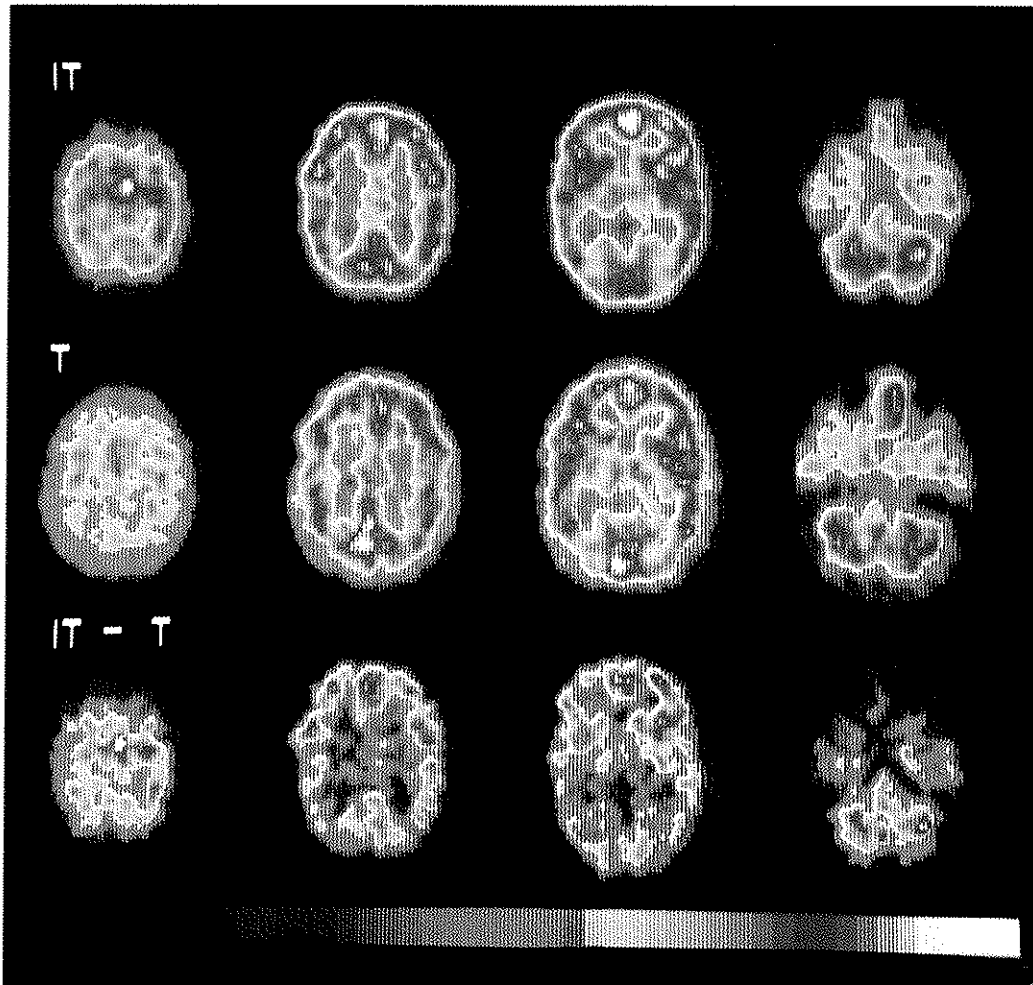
HM-PAO brain SPECT of one subject. Four axial slices from cranial (left) to caudal (right). Upper row: Inverted Tracking (IT); middle row: Tracking (T); lower row: subtraction (IT minus T) after normalization of count rates. The relative tracer distribution is displayed in colours ranging from blue (low) to white (high concentration). In the lower row, colours of red and white display areas having a higher relative tracer concentration in IT as compared to T. This is particularly true in the mesial fronto-central cortex, the dorso-lateral cortex of both hemispheres (mainly congruent with the middle frontal gyrus), basal ganglia and cerebellum. From Lang *et al.*, 1988a.
